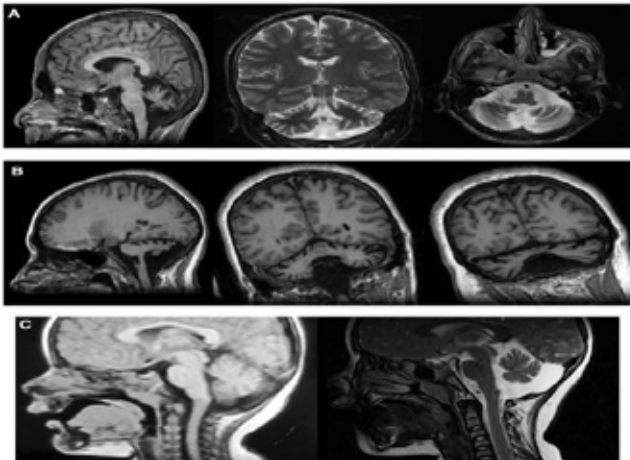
Brain Imaging of the Patients with Congenital Cerebellar Ataxia (A) Generalized cerebellar atrophy and inferior vermian hypoplasia in patient P II-2 (B) Moderate to severe cerebellar atrophy and inferior vermian hypoplasia in patient B IV-3 (C) Evolution of MRI changes in patient V III-2. The left panel shows normal findings at age 1 year and 8 months, and the right panel shows moderate to marked cerebellar evident at 6 years of age.
